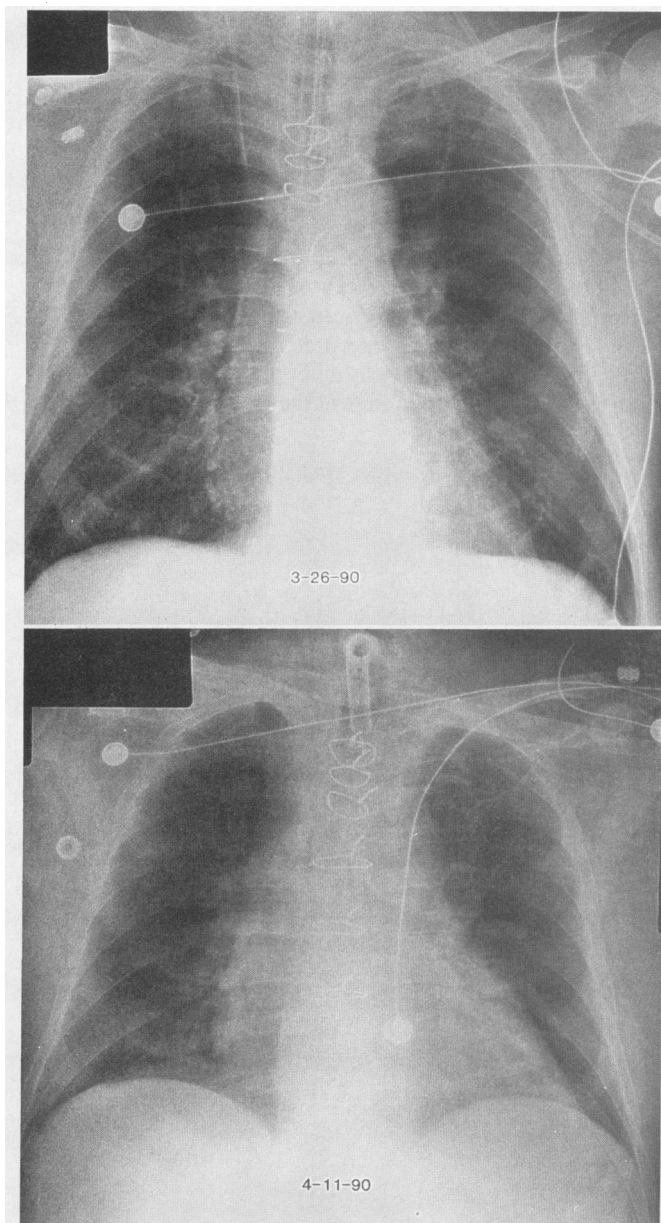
Top, A posteroanterior chest radiograph on hospital day 9 shows clear lung parenchyma despite concurrent lung uptake of radioactive indium (Figure 1). Bottom, A follow-up posteroanterior chest radiograph was taken on day 25.
